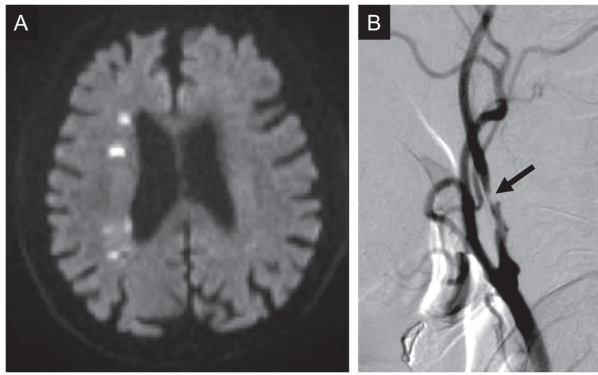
A 79-year-old male with symptomatic stenosis of the right cervical internal carotid artery. (A) Diffusion-weighted image on preoperative MRI. Multiple high-signal-intensity lesions were detected in the right cerebral hemisphere white matter and cortex. (B) Lateral cervical view on preoperative right common carotid angiography. Marked stenosis of the internal carotid artery (arrow) was observed.
